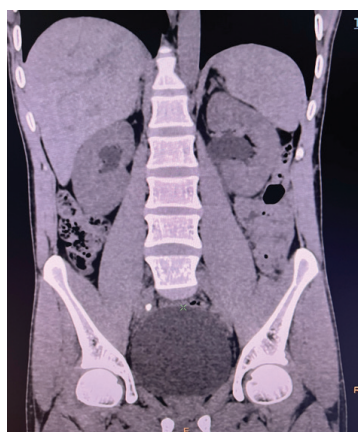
Plain CT KUB showing right mid ureteric calculus
